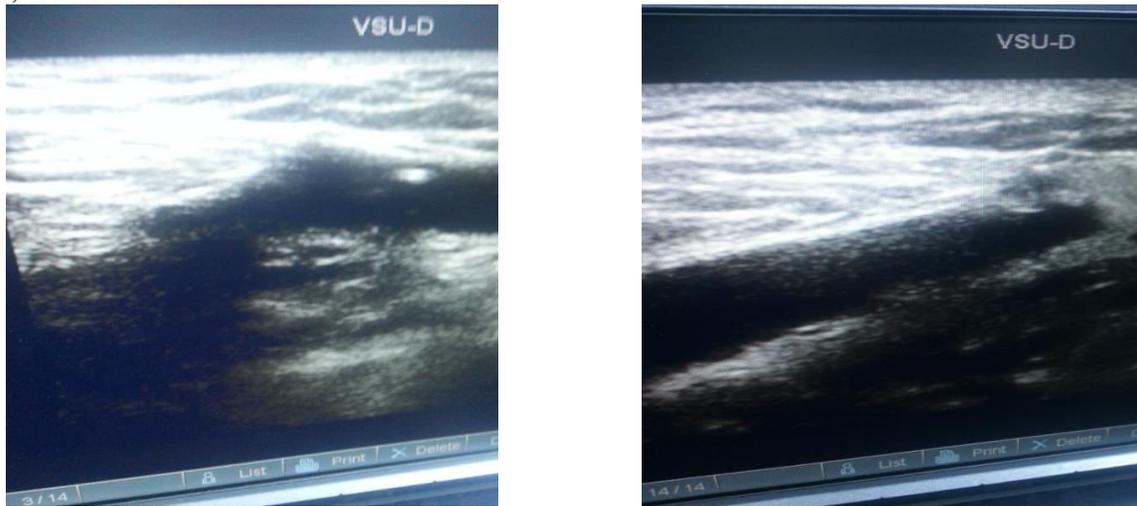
Ultrasound showing Tip of cath. at SFJ, and pulsed injected saline
